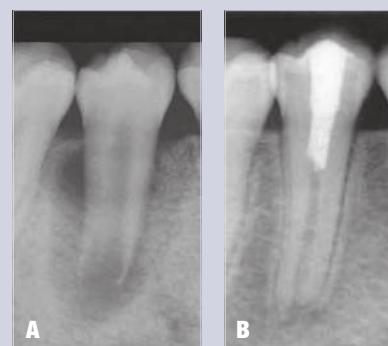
(A) Preoperative radiograph of tooth #29. (B) 24-month follow-up after regenerative endodontic treatment. Reprinted with permission from Banchs F, Trope M. Revascularization of immature permanent teeth with apical periodontitis: new treatment protocol? J Endod 2004;30:196-200.
